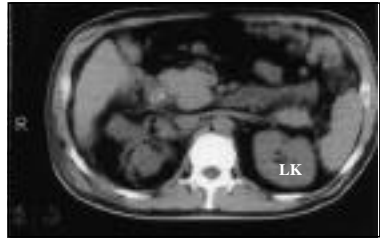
Abdominal CT of the patient after right nephrectomy (LK - left kidney).
